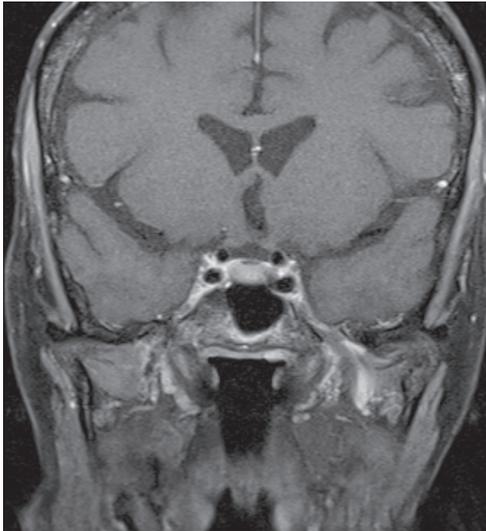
Coronal T1W post contrast MRI at the level of the cavernous sinus confirms bilateral cavernous sinus thrombosis .
